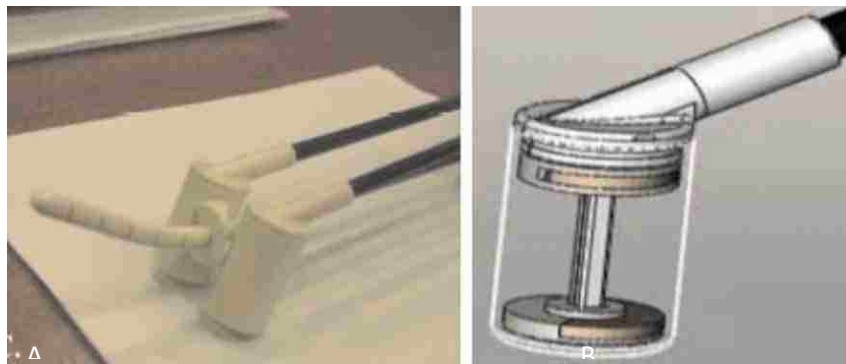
Price's CT/MR compatible shielded A³ applicator. The external appearance of the applicator (A) and interovoid shields (B). (Price, 2008)
